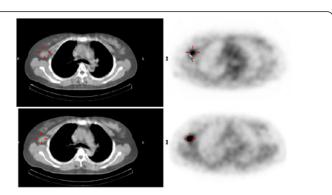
The pre-(above) and post-treatment (below) CT imaging(A) and hybrid ¹⁸F-FDG PET imaging (B) in a breast cancer patient with a response to neoadjuvant chemotherapy. After neoadjuvant chemotherapy, the radioactivity of ¹⁸F-FDG in breast cancer area decreased significantly, with the tumor to non-tumor FDG radioactivity ratio decreasing from 2.58 to 1.94.
